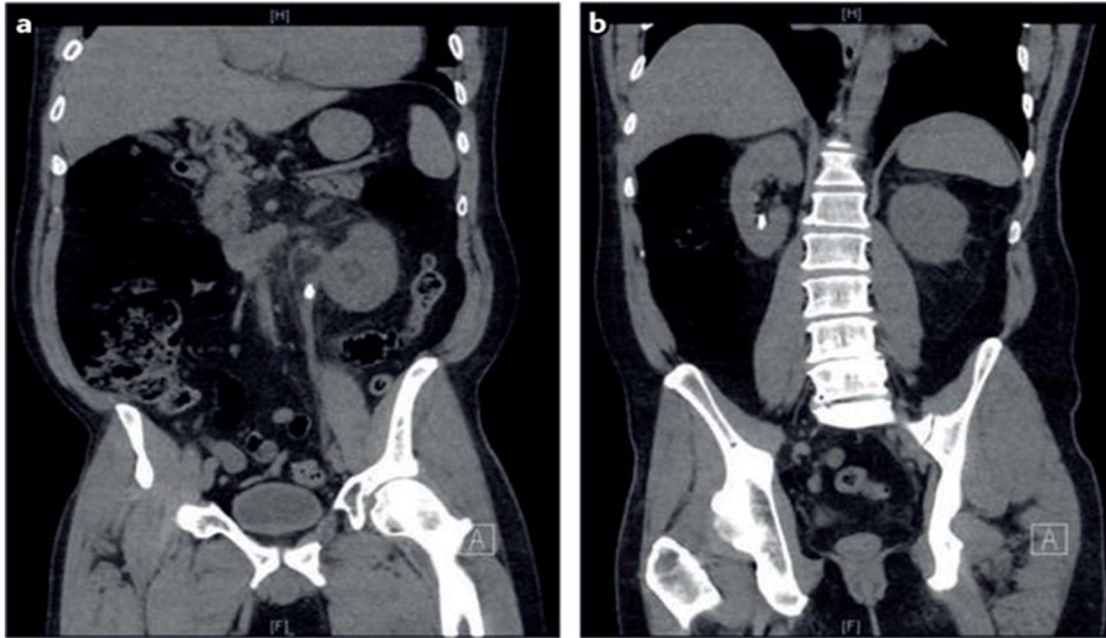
A bilateral 8 mm nephrolithiasis on a noncontrast CT scan, as seen in the coronal view.
